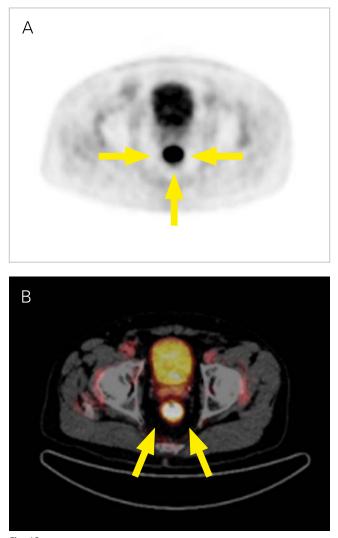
Imaging of rectal carcinoma with positron emission tomography (PET) (A) and combined PET/CT (B); arrows indicate the tumour
